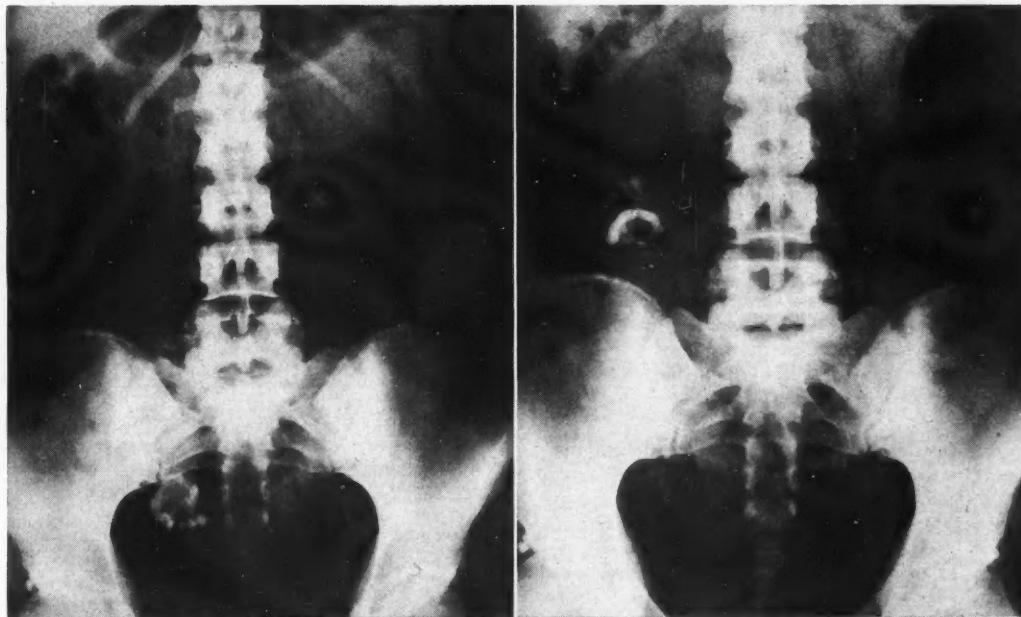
Left:* The preliminary roentgenogram disclosing dental and osseous elements on the right side of the pelvis within a rounded cystic area of radiolucency, completely encircled by a dense rim of fibrous capsule. *Right:* Anteroposterior roentgenogram of the abdomen, demonstrating the abdominal position of the mobile mass, now overlying the inferior pole of the right kidney.
